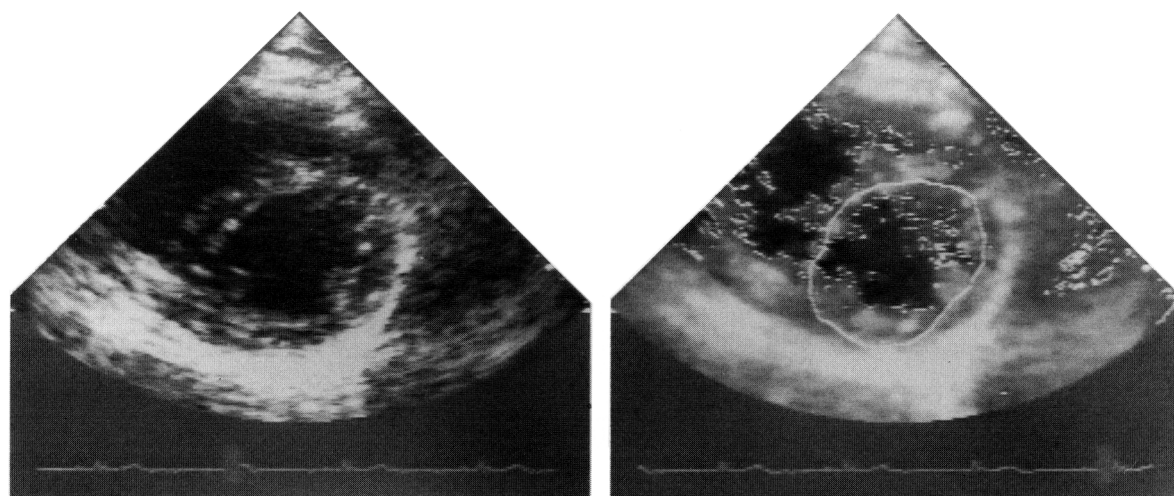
Images from the high-gain training group. Left panel: Conventional echo of left ventricle (parasternal short-axis view). The endocardial edge was considered to be the interface between the bright endocardial echoes and the dark cavity of the left ventricle. Right panel: Real-time border detection system. To identify endocardial interfaces parallel to the ultrasound beam (i.e., medial and lateral walls), increased transmit and time-gain compensation was necessary, leading to the appearance of cavity clutter.
